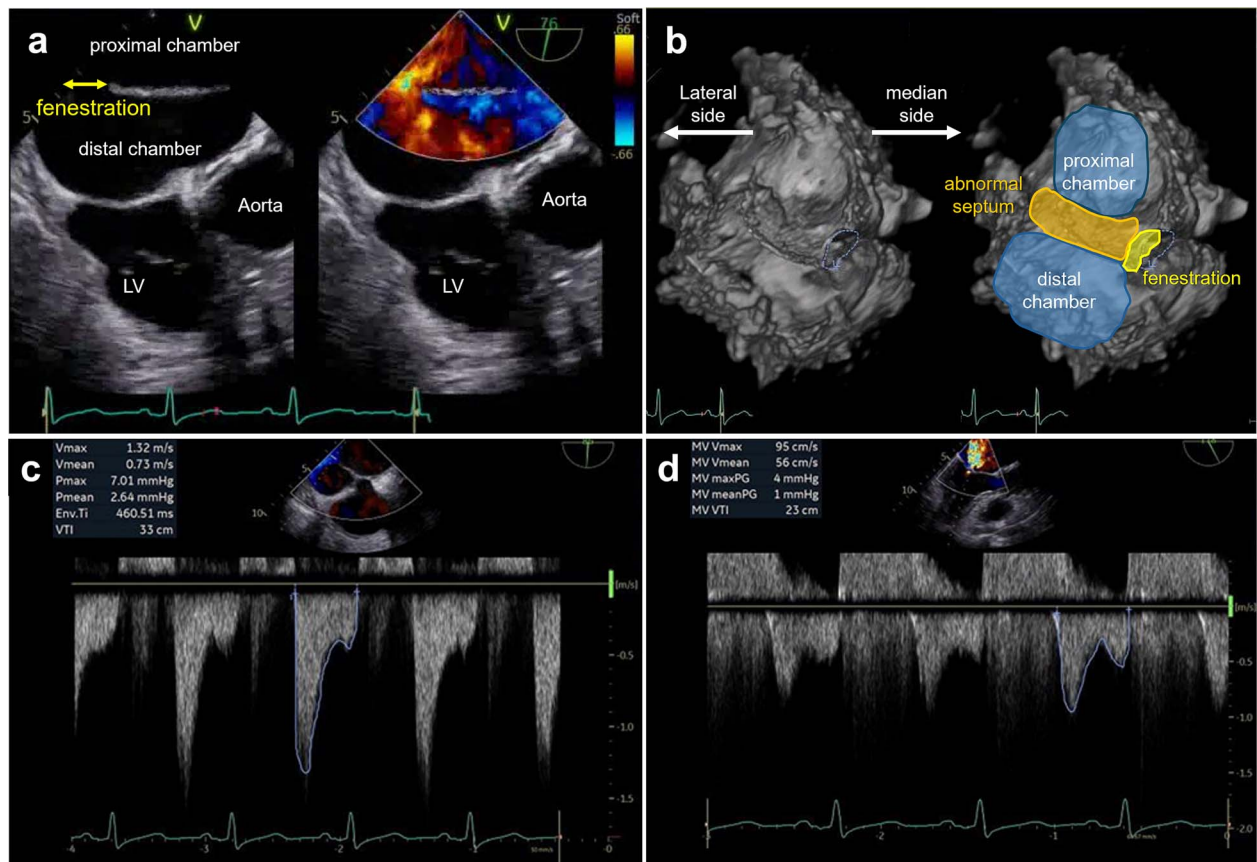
Transesophageal echocardiography after initial treatment. (a) The fenestration site was only detected in the median side of the left atrium. (b) Three-dimensional imaging of left atrium. The area of fenestration site was 1.5 cm². Continuous wave Doppler flow pattern between proximal and distal chamber with the pressure gradient at 2.6 mmHg (c), and between distal chamber and LV with the pressure gradient at 1.0 mmHg (d). LV, left ventricle; V max, velocity max; V mean, velocity mean; P max, pressure max; P mean, pressure mean; Env. Ti, envelope time; VTI, velocity time integral; PG, pressure gradient.
